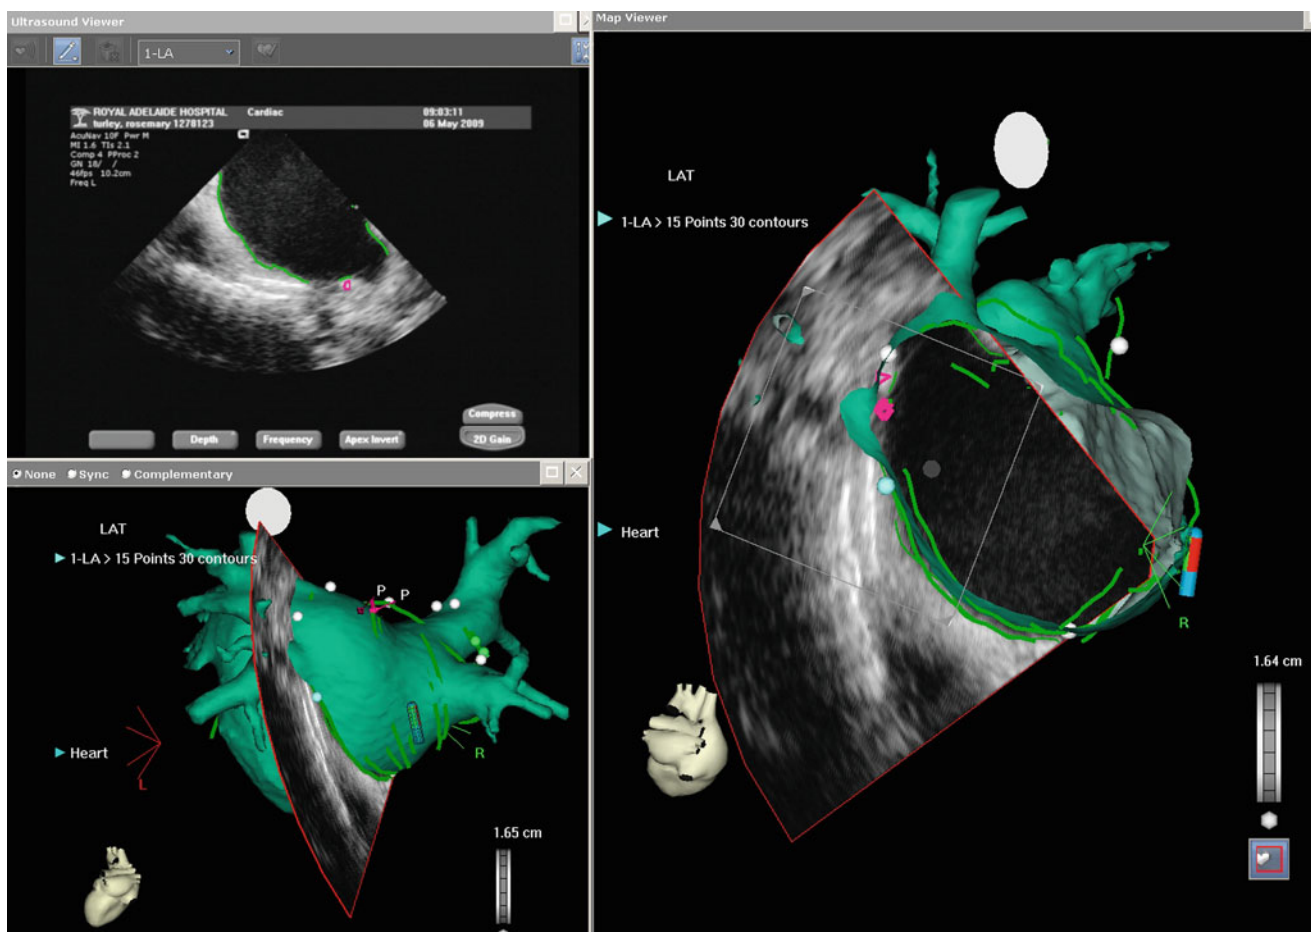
A screen capture from CARTO-sound anatomical map development showing a 2D echocardiography slice taken from the right atrium, highlighting the carina of the left pulmonary veins (pink dot). The Sound-Star catheter tip in the right atrium, its orientation and slice angle are seen clearly in the right-sided image. Outlines demonstrate
